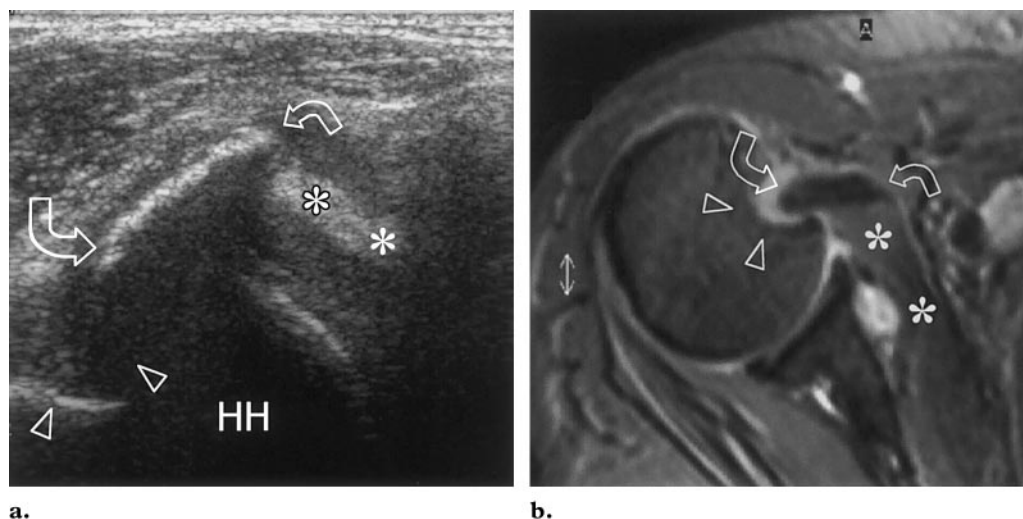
Avulsion fracture of the lesser tuberosity in a 54-year-old woman with posterior shoulder instability. (a) Transverse 12–5-MHz US image obtained over the anterior shoulder shows a large fleck of bone (arrows) avulsed from the humeral head (*HH*). Note the deep defect (arrowheads) on the anterior surface of the humerus and the continuity of the avulsed bone with the subscapularis tendon (*). (b) Corresponding GRE MR image (500/15/20°) shows the avulsed bone fragment (arrows), the humeral defect (arrowheads), and the subscapularis tendon (*).
